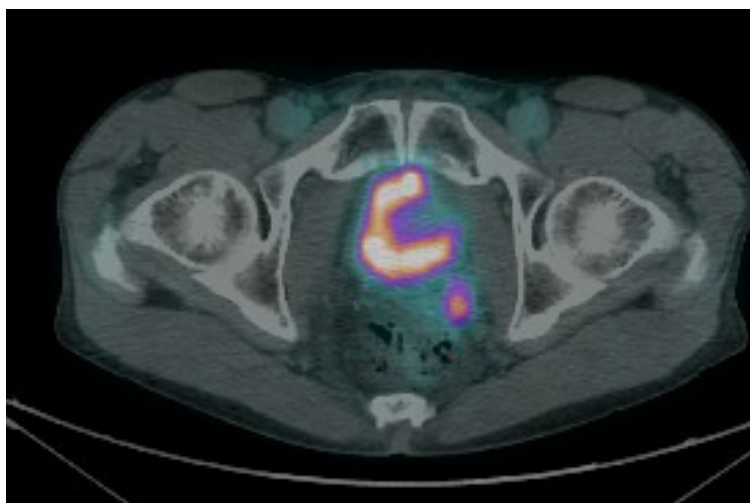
Rising PSA was noted in a patient with previous history of prostate cancer, left seminal vesicle involvement, which was removed at surgery and then treated with radiotherapy. ⁶⁸Gallium PSMA PET/CT showed focal area of uptake at the poster aspect of the bladder on the left side with soft tissue abnormality on the low dose CT. This is in keeping with disease relapse.
